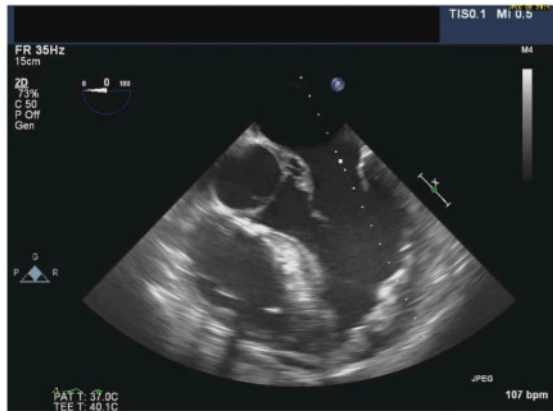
Transoesophageal echocardiogram (five-chamber view/2D) showing the aortic root abscess.
